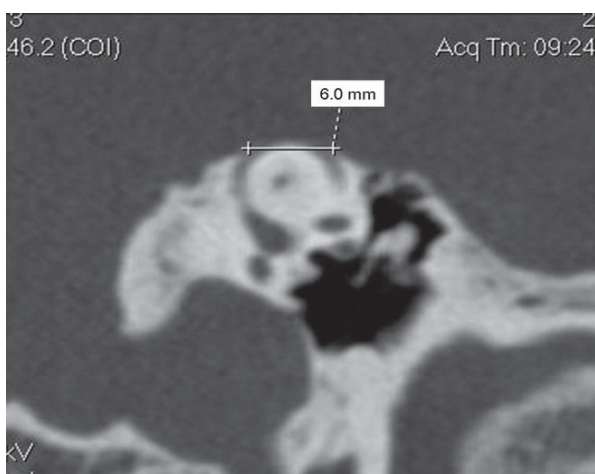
A reformatted oblique sagittal CT scan image of patient number 8 showing a 6.0-mm dehiscence over the apex of the superior semicircular canal.
